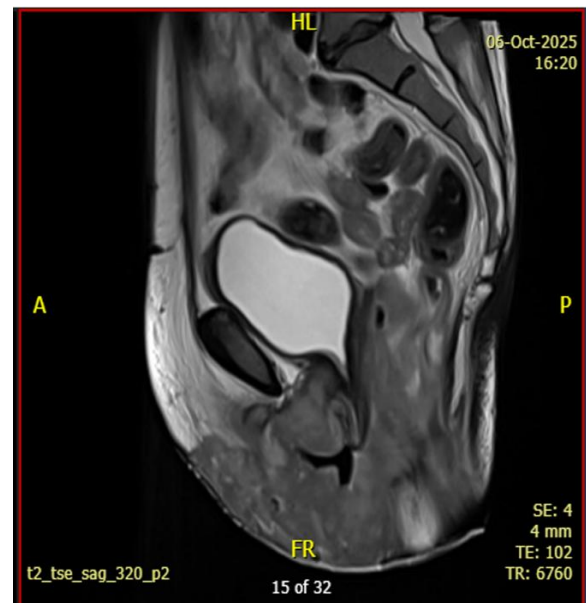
MRI sagittal view showing extensive abnormal soft tissue.
